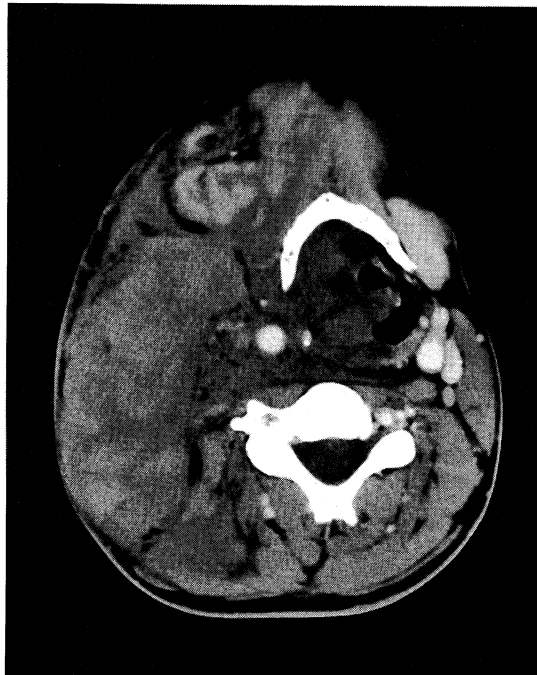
Computed tomography (CT) shows a huge hematoma in the right neck region.
